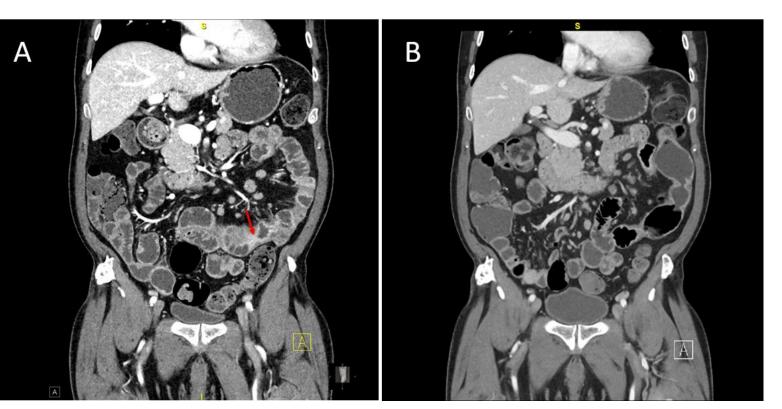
Panel A: CT Enterography, performed prior to treatment initiation. with evidence of jejunal stricture (red arrow) with associated wall thickening and inflammation. Panel B: CT Abdomen with IV contrast, performed three months after the initiation of vedolizumab. with evidence of interval improvement of jejunal wall thickening and mucosal hyperenhancement
